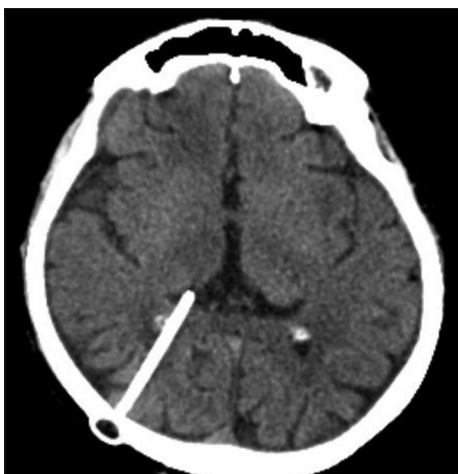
Postoperative brain computed tomography shows resolution of hydrocephalus following ventriculoperitoneal shunt insertion
